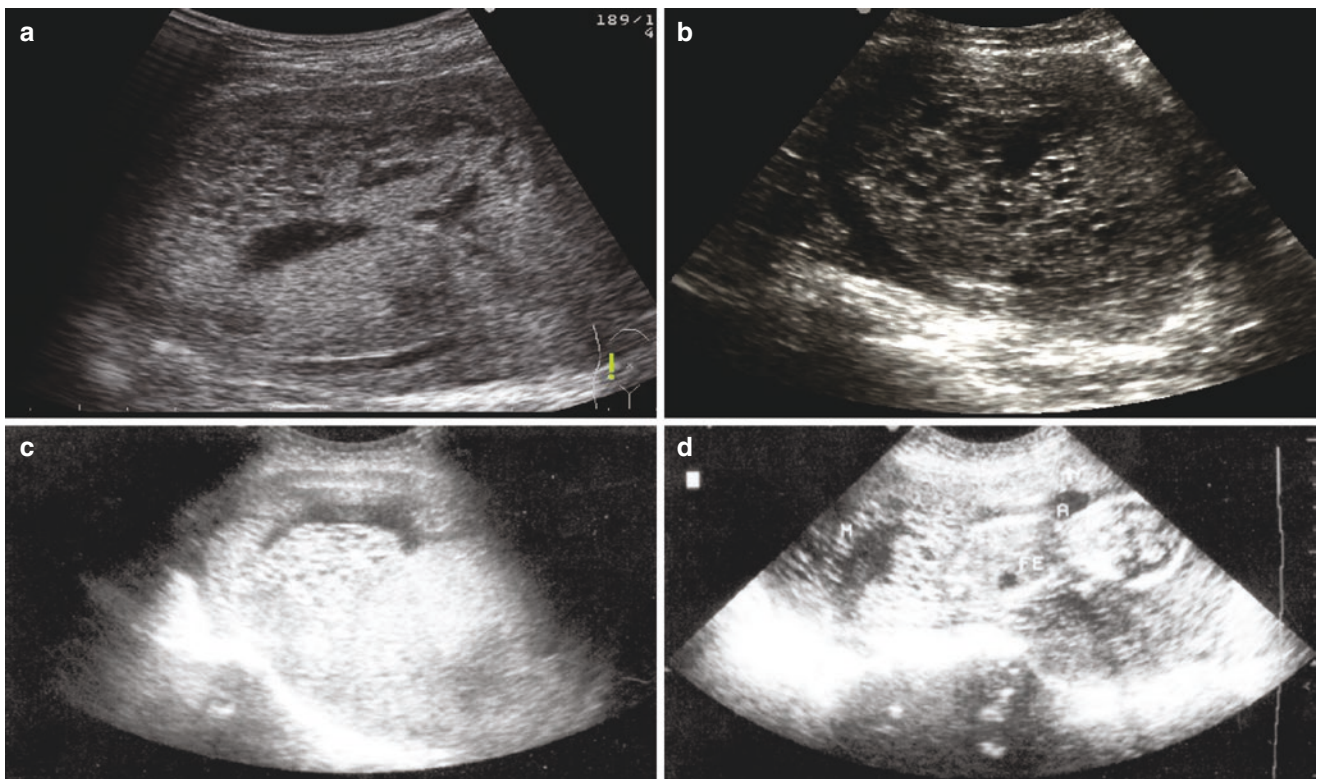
Hydatidiform mole (I). (a–c). complete hydatidiform mole, uterus is enlarged than the gestational age, with intrauterine “honeycomb” echo; (d). 14 weeks of amenorrhea, sonogram shows a normal fetus and part of the placenta appears the “honeycomb” echo
